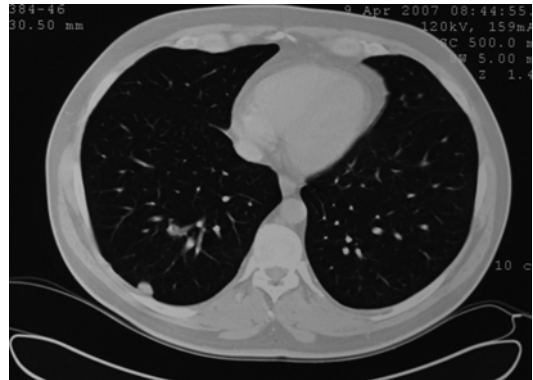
Thoracic CT showing lung metastasis
